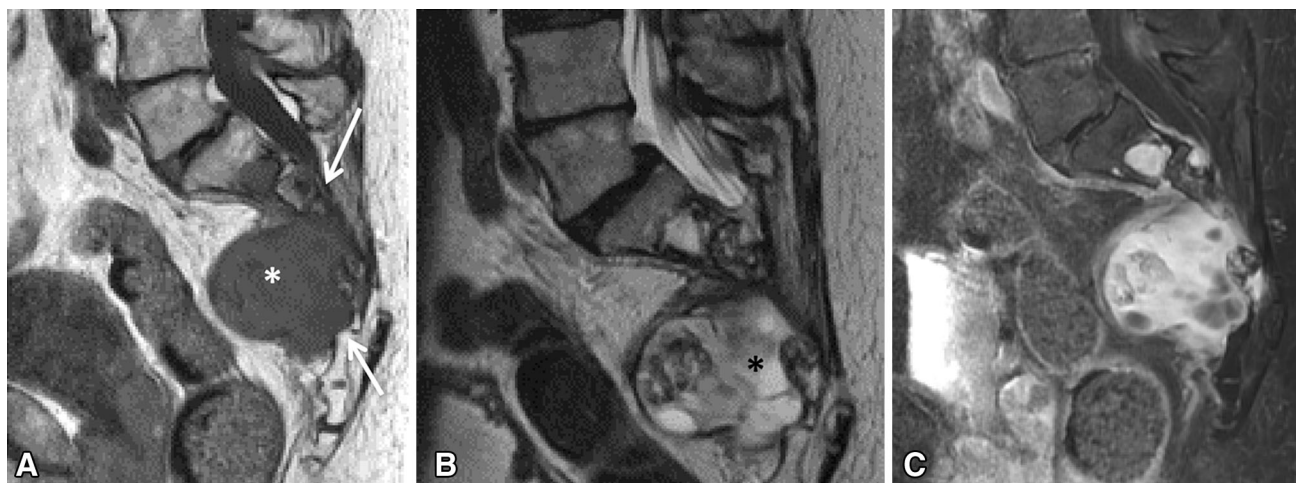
Biopsy proven sacral schwannoma. A Sagittal T1-weighted image demonstrates a low T1 signal intensity mass (asterisk) in the presacral space with erosion and remodeling of the sacrum (arrows). B Sagittal T2-weighted image shows
